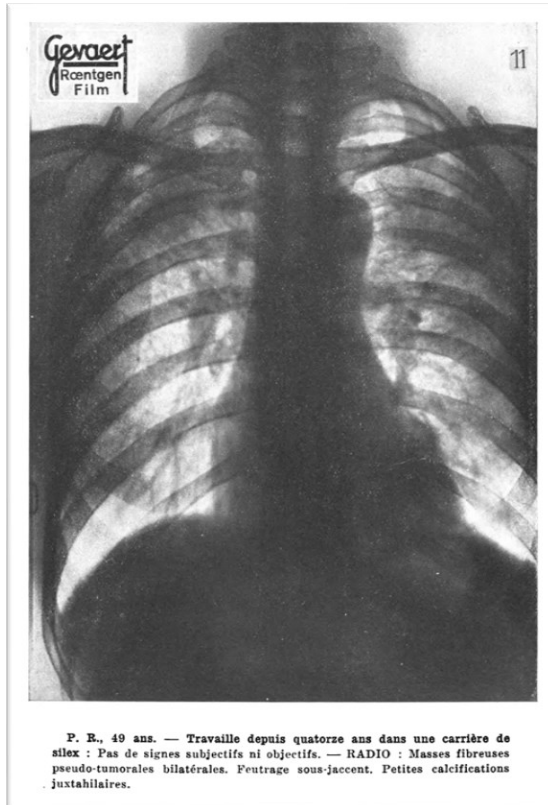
Because of the 1930 ILO Johannesburg Conference on Silicosis, silicosis became internationally recognized as an occupational disease. As there was barely anything known on the situation in Belgium, the labour inspection did, in 1935, a study to assess if silicosis also existed in Belgium (“La silicose existe-t-elle en Belgique?”). The answer was yes. This chest X-rays shows progressive massive fibrosis in a 49-year-old man having worked for 14 years at a silex quarry. Silex contains between 90 and 95% quartz. The caption mentions that he had “no subjective symptoms, nor objective signs” [From: Langelez A. (1937), *Enquête Organisée Par Le Service Médical Du Travail Au Sujet de La Silicose—Industries Autres Que Les Mines*]¹
